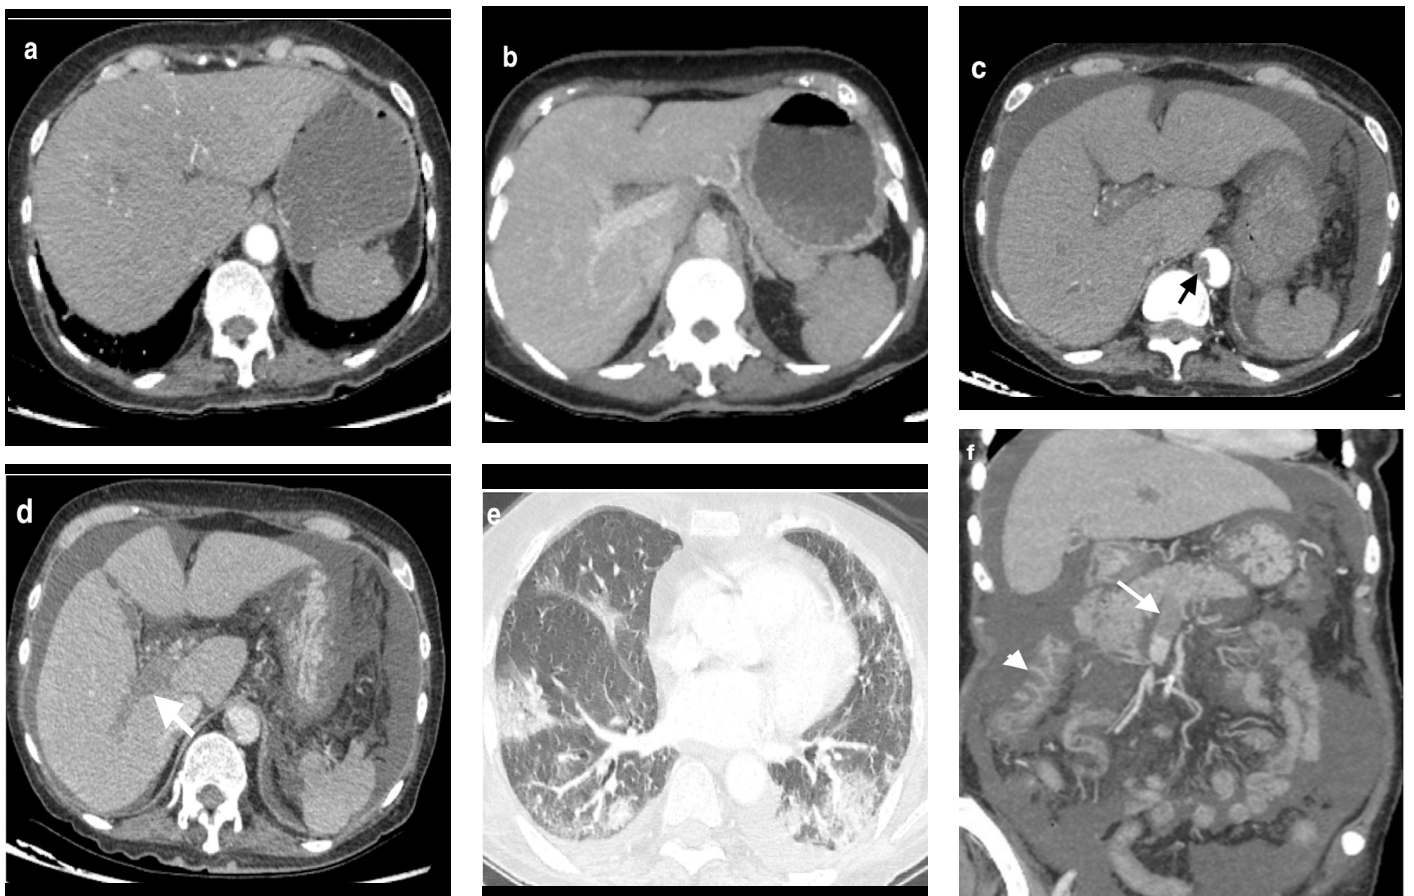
Acute superior mesenteric vein thrombosis. A 74-year-old woman with acute myeloid leukemia who presented with shortness of breath, abdominal pain, and diarrhea was diagnosed with coronavirus disease-2019. Axial contrast-enhanced abdominal computed tomography (CT) images (a, b) obtained 1 month before hospital admission reveal patent abdominal aorta and right portal vein. Axial arterial phase contrast-enhanced CT image obtained on hospital admission (c) demonstrating an acute thrombus in the abdominal aorta (arrow). Axial portal venous phase contrast-enhanced CT image (d) reveals an acute thrombus in the right portal vein (arrow). Axial chest CT image (e) demonstrating bilateral ground-glass opacities in both lungs. Coronal-reformatted abdominal CT image (f) showing an acute thrombus in the superior mesenteric vein (arrow). Note the bowel wall thickening of the ascending colon (arrowhead) and ascites.
